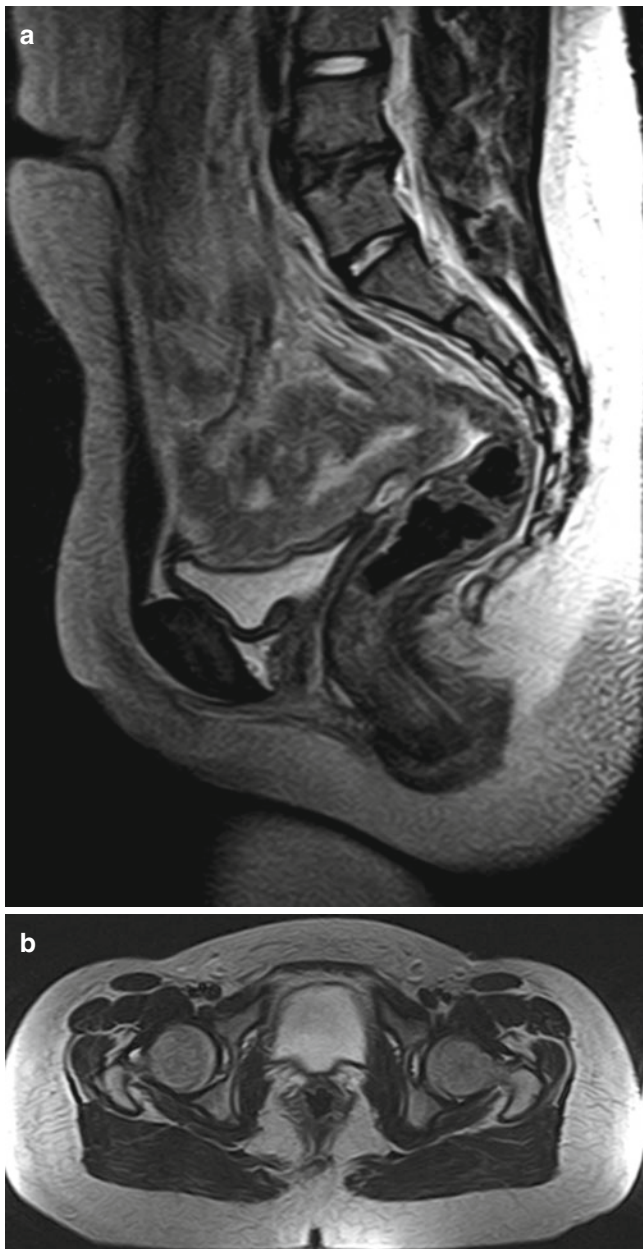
Aplasia of the entire segments of uterus and vagina (Mayer-Rokitansky-Küster-Hauser syndrome) in a 14-year-old patient. (a) Midsagittal T2-weighted MR image reveals no vagina and uterus. (b) Axial T2WI at the level of the femur head shows no vagina between the bladder and the rectum
